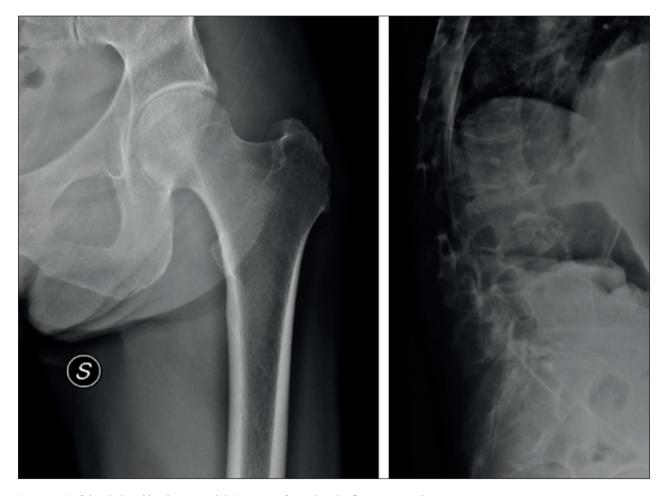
Left hip (A) and lumbar spine (B) X-rays performed at the first access to the emergency room
